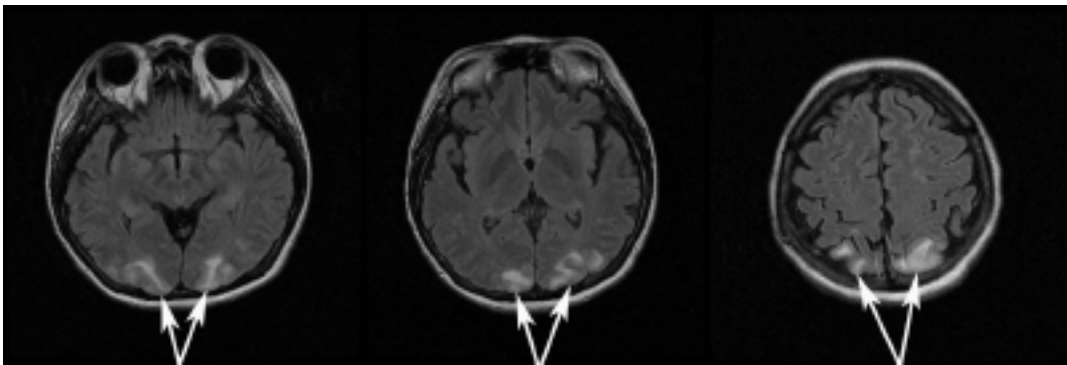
Brain MRI scans of Patient 1 show increased T2 fluid-attenuated inversion recovery (FLAIR) predominantly in the white matter of the occipital lobe (arrows).
